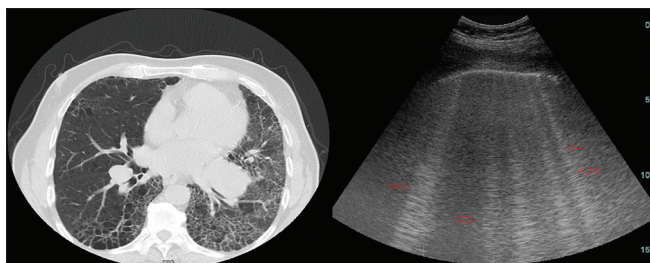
The comet tail artifacts detected using thorax ultrasonography in the patient who had changes on thorax high resolution computed tomography compatible with the interstitial lung disease (comet tail artifacts were demonstrated with red arrow)
